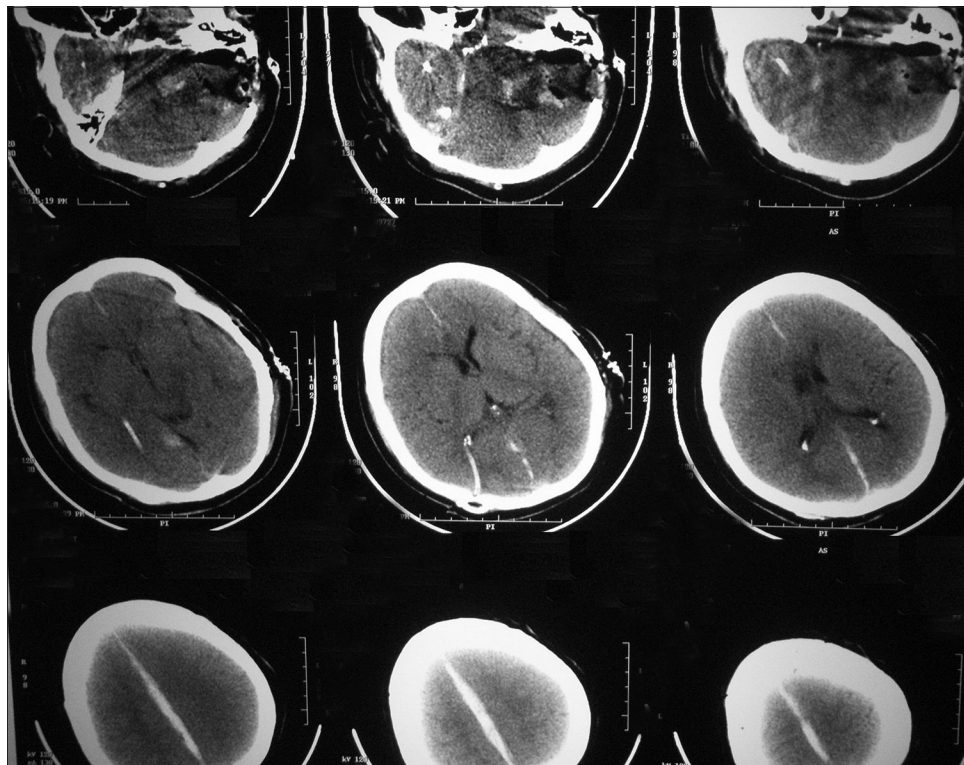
Immediate postoperative CT scan showing small blood specks in the tumor bed and small amount of interhemispheric fissure bleed
